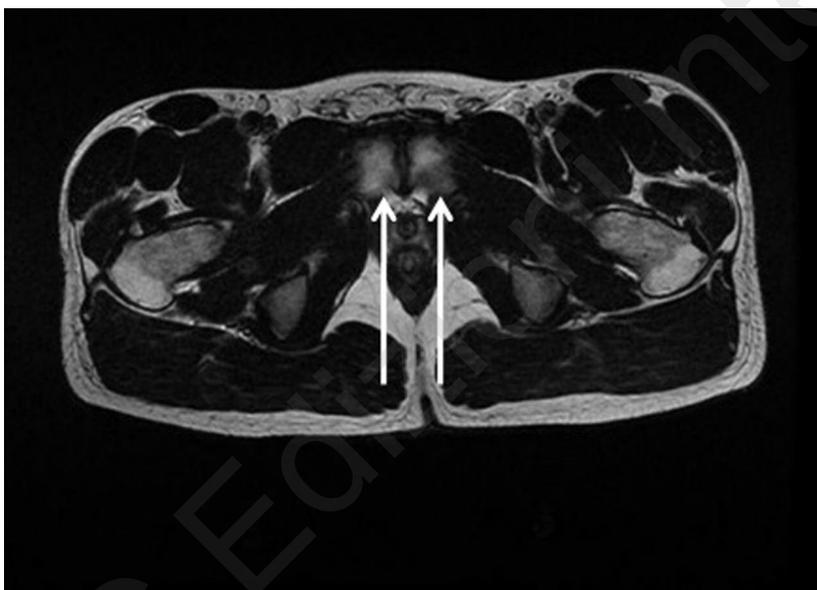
Axial oblique T2 MRI showing a BMO extended across the surface, in the antero-posterior direction. Of both the pubic branches. Depending on its extension, the BMO is classified as grade 3.
